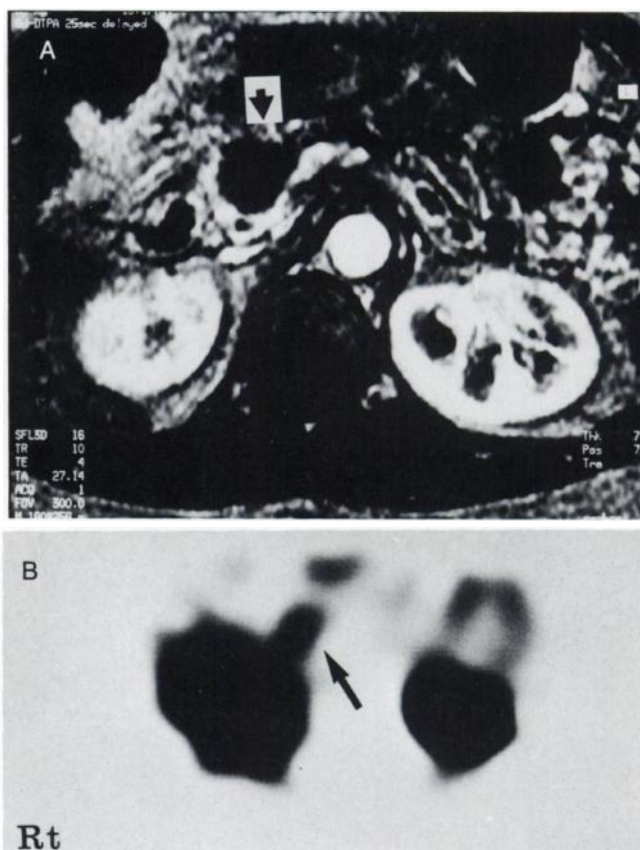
A 61-yr-old woman with a tubular adenocarcinoma, which was one of the smallest cancers positively depicted in our series. (A) Dynamic contrast-enhanced, three-dimensional, fast, low-angle image obtained 25 sec p.i. (10/4/1; TR/TE/excitation, flip angle; 16°) shows a hypointense 25 × 20-mm tumor in the pancreas head (→). (B) Thallium-201 SPECT image shows intense uptake corresponding to the tumor, with an L/H ratio of 0.73 (→).
